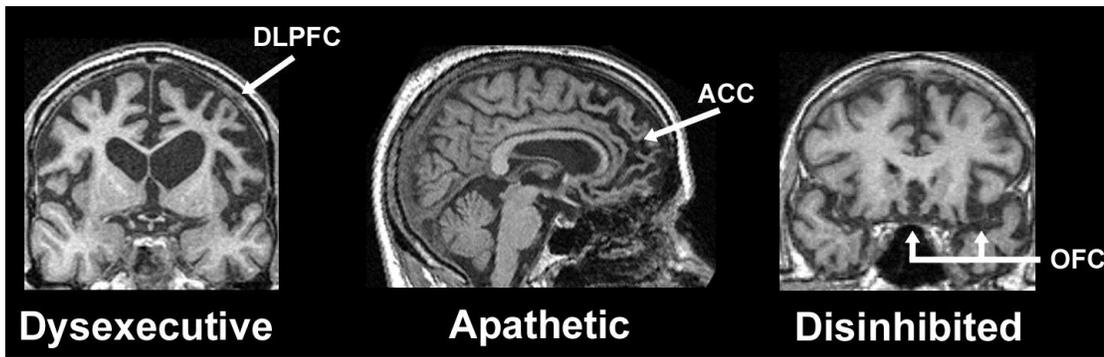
Frontal symptoms relate to the localization of frontal injury. Representative T1-weighted MR images and presenting symptoms are listed for three contrasting patients with degenerative dementia.
